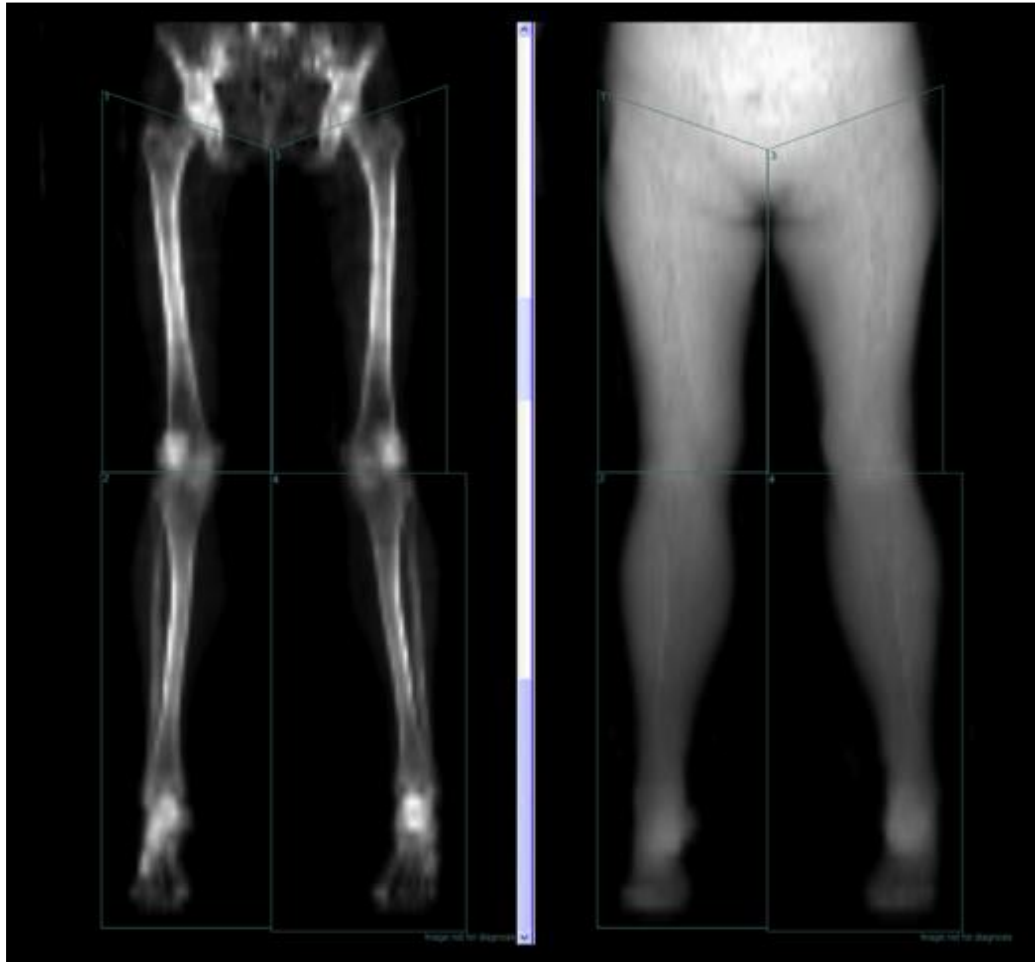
Dual-energy X-ray absorptiometry planograms windowed for skeleton and soft tissue. Boxes are drawn around the regions of interest using the definitions described above.
